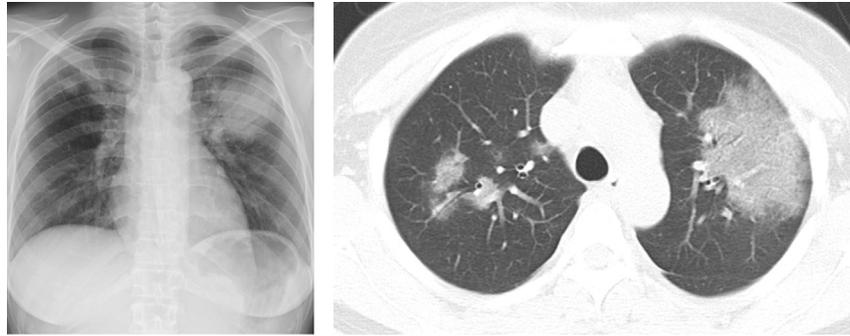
Chest radiograph (left) and CT imaging (right) for Case 2. The chest X-ray and CT scan revealed left dominant bilateral ground-glass opacities.
